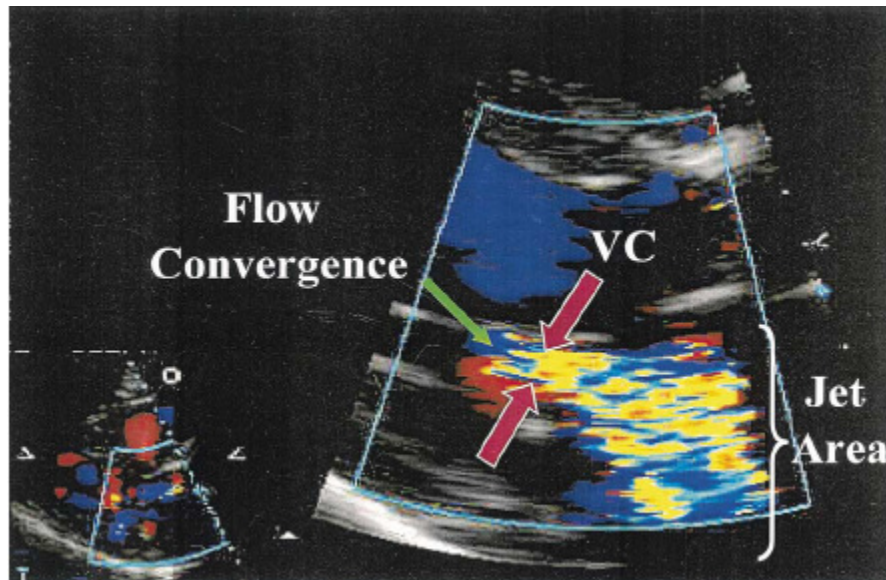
Colour flow recording of a MR jet obtained from a zoomed view in the parasternal long axis. The 3 components of the regurgitant jet are: flow convergence, VC and jet area in the LA. Measurement of the VC is shown between the red arrows (Zoghbi *et al.*, 2003).
